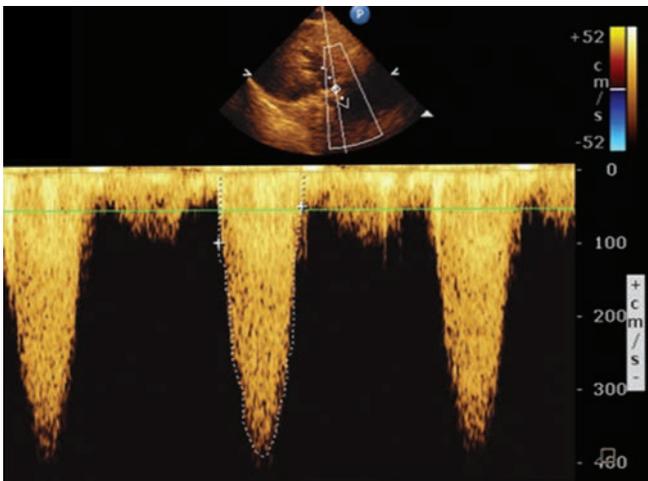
TEE Continuous wave Doppler. Also shows high gradients across the tissue AVR (Transgastric view). V_{\max} (maximum peak velocity) = 390 cm/s, VTI (Velocity time integral) = 54.6 cm, maximum peak gradient (PG) = 61 mm Hg, Mean PG = 35.9 mm Hg.
